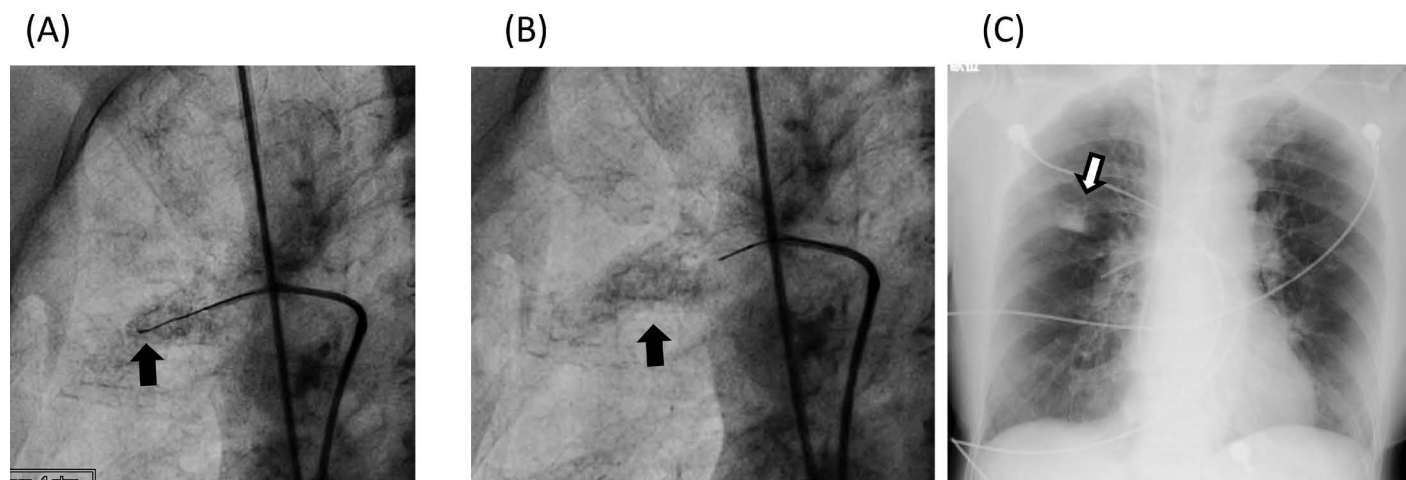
Lung injury caused by wire perforation during balloon pulmonary angioplasty. (A) Intervention wire. Arrow: wire and consolidation around the tip of wire. (B) After pullback of wire. Arrow: consolidation. (C) Chest x-ray image after balloon pulmonary angioplasty. Arrow: consolidation.
